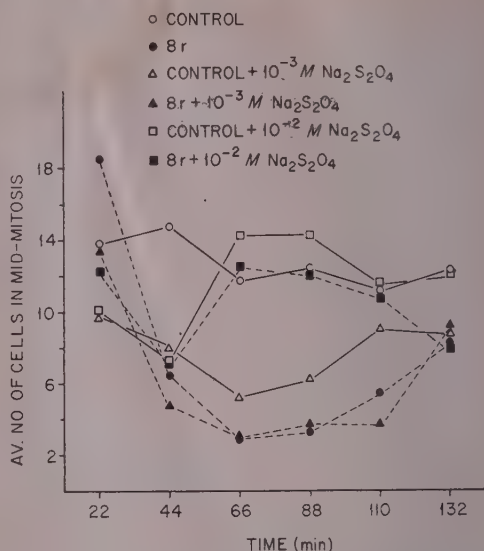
Effects of X-rays on mitotic activity of grasshopper neuroblast in pretreated and untreated cultures.
